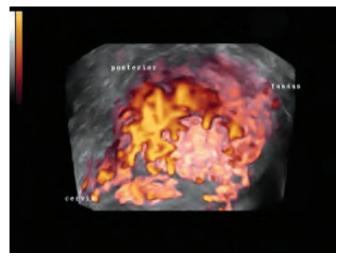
3D power-Doppler flow mapping of the figures 11.20 and 11.21 tumor. The surface of tumor is covered by the blood flow *Courtesy:* U Honemeyer
